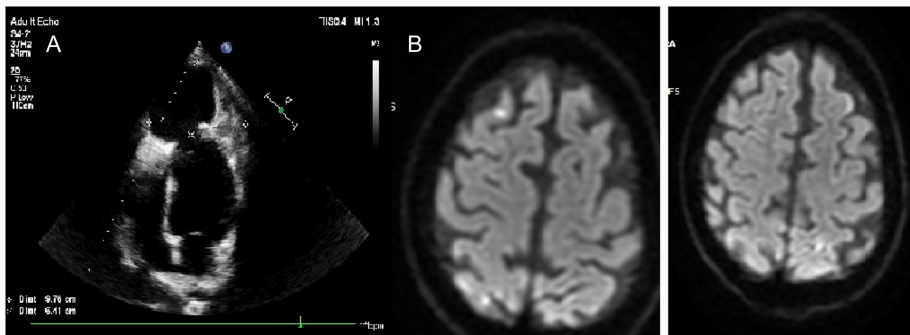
(A) A transthoracic echocardiography was performed in the emergency department, revealing a giant 9 cm diameter pseudoaneurysm with a mobile thrombus. (B) On diffusion-weighted magnetic resonance imaging, a small focal diffusion restriction at the vertex level in the right frontal lobe and diffuse cortical diffusion restriction in the bilateral posterior parietal lobes were observed.
